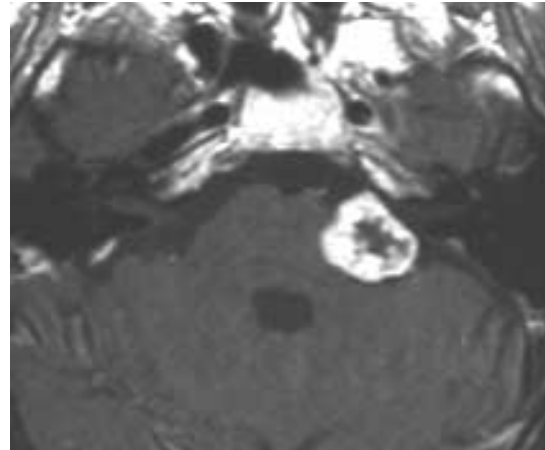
MRI: Axial gadolinium-enhanced T1 sequence. Well-circumscribed and heterogeneous lesion is shown compressing the left pons.
